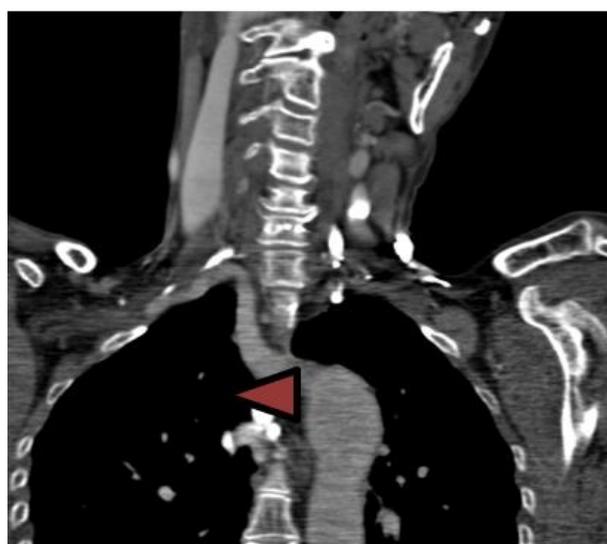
Postcontrast Computed Tomography – Angiography coronal image Arteria lusoria originates from the aortic arch (arrow head), crosses the midline between the spine and the oesophagus to reach the right side
